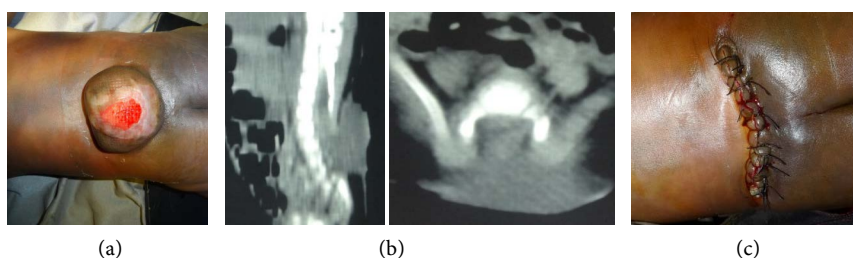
(a) Clinical photograph of myelomeningocele; (b) CT scan showing the bone defect; (c) Clinical photograph after surgical repair.
